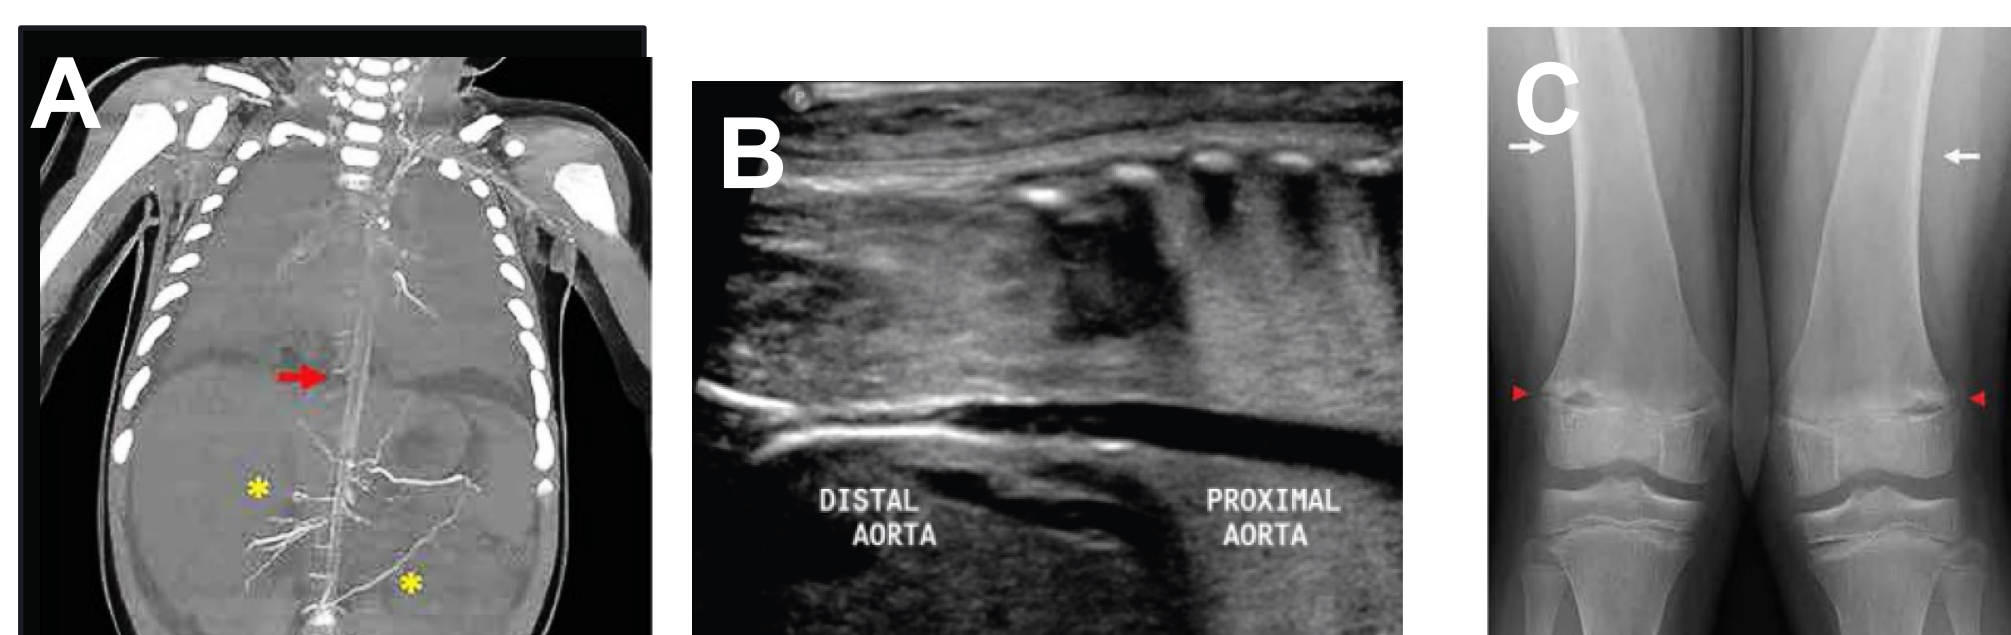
A. CT showing arterial calcification. B. Ultrasound showing calcification of the aorta. C. Radiographs demonstrating genu valgum secondary to hypophosphatemic rickets
